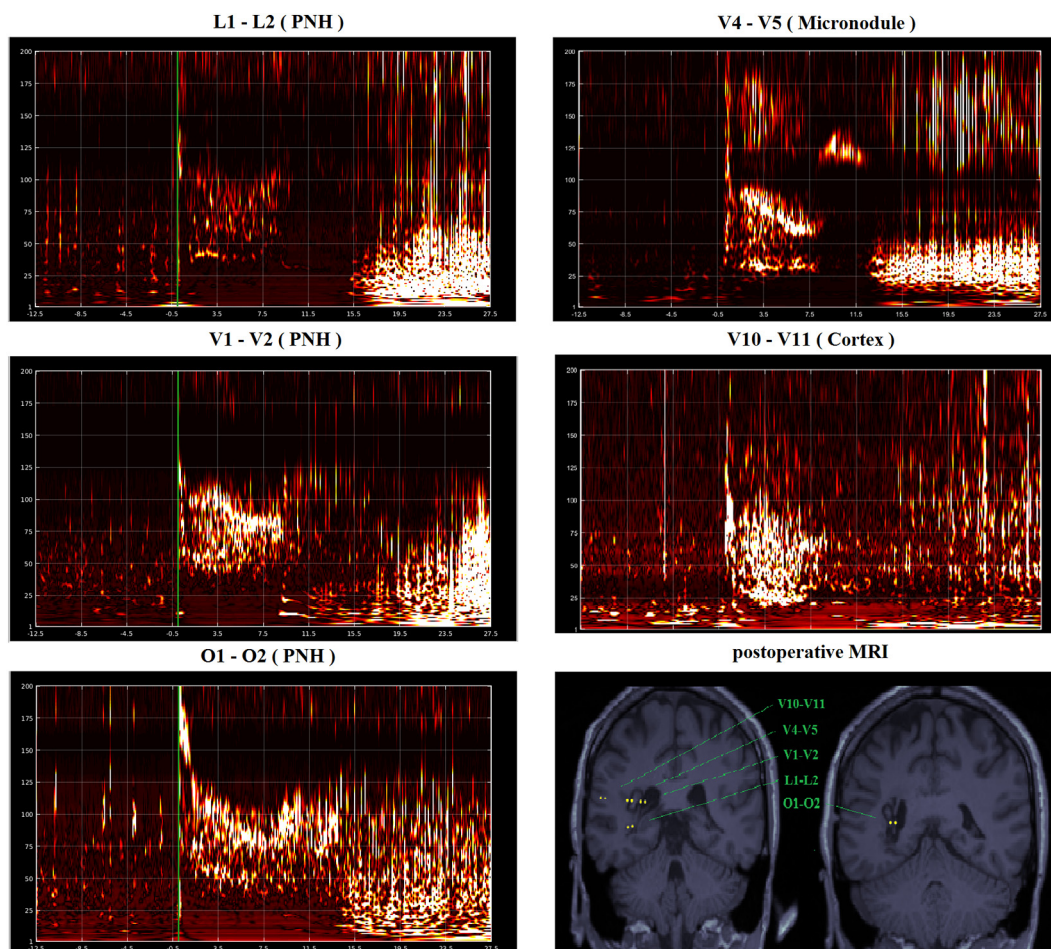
Post-operative MRI shows SEEG-guided ablation of heterotopic nodules and adjacent white matter. The time-frequency plots of each contact pair at the pre-ictal to ictal transition shows the combination of features of pre-ictal spikes, multiband fast activity and simultaneous suppression of slower background frequencies. The contact pairs (L1–L2, V1–V2 and O1–2) in the periventricular nodular heterotopia (PNH) were identified by the machine learning algorithm classifier as showing features consistent with the epileptogenic zone based on the fingerprint analysis. Note that the contact pairs which were positive for the fingerprint of the epileptogenic zone all lie in the ablated zones. In comparison, contacts in the cortex (V10–V11) were not identified by the classifier as having features of the epileptogenic zone. Notably there is no clear suppression of frequencies or multiband fast activity. The contact pairs in the micronodule (V4–V5) show some features of the fingerprint on visual analysis but were not identified by the classifier as significant.
